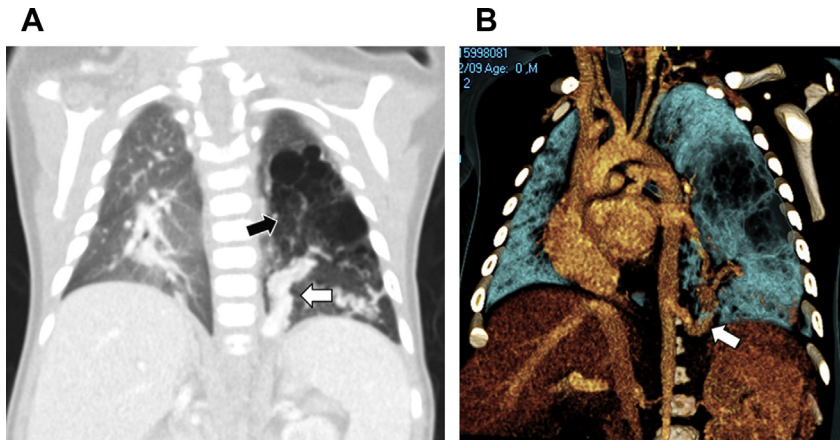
A 5-month-old boy with congenital pulmonary airway malformation (CPAM) and bronchopulmonary sequestration (hybrid lesion) (same patient as Fig. 2). (A) Coronal image from contrast-enhanced CT angiography (CTA) demonstrates an air-filled multicystic lesion within the left lung (*black arrow*) with a large feeding systemic artery (*white arrow*). (B) Three-dimensional (3D) volume-rendered CT image shows the systemic feeding artery (*arrow*) arising from the aorta.
